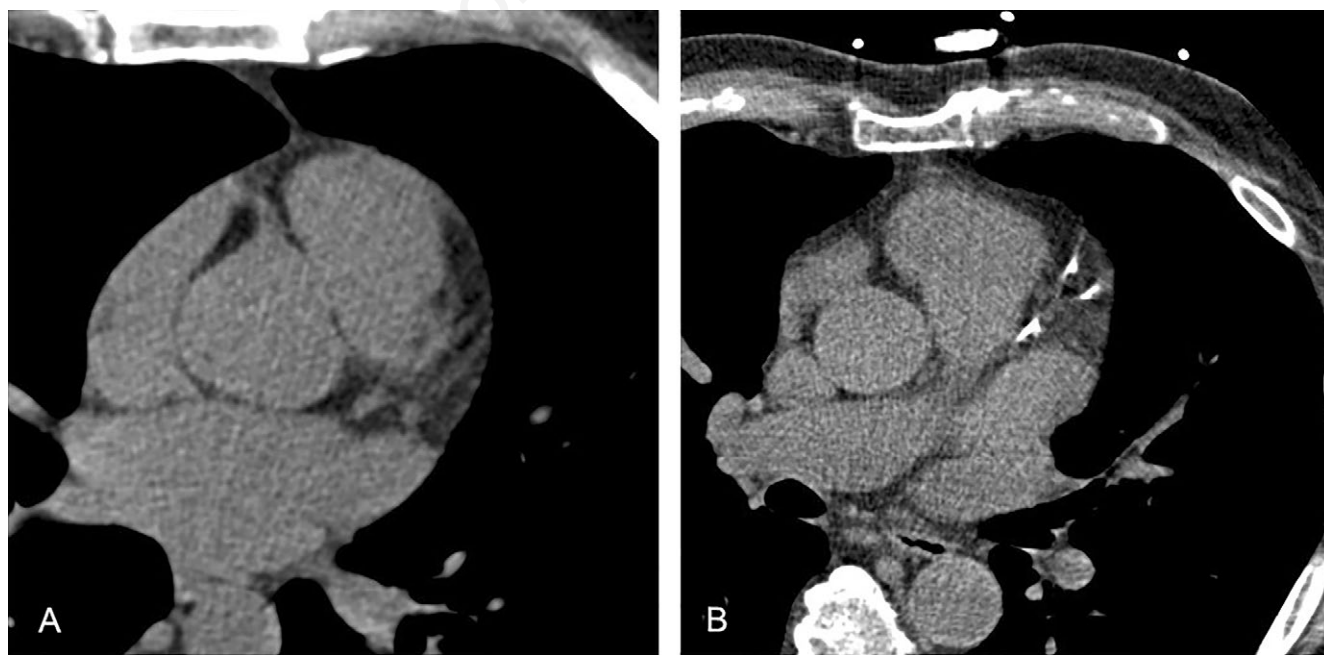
Computed tomography of the heart. Left: absence of calcification on the coronary tree; right: presence of diffuse calcification on the coronary arteries.
